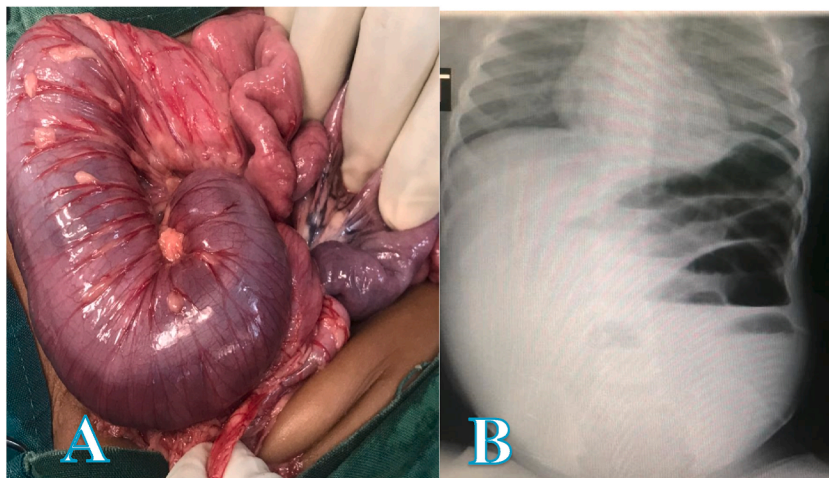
A) Ileo-colic intussusception segment of gangrenous bowel B) showing an abdominal x-ray with air-fluid levels.
